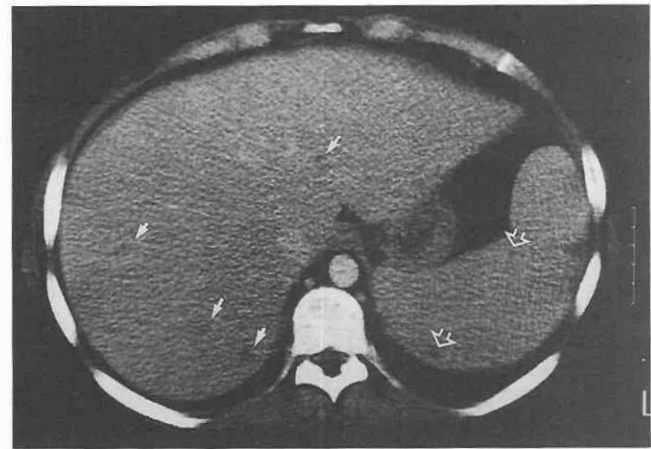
Candidal abscesses. CT image in an immunosuppressed child reveals multiple small low-attenuation microabscesses (arrows) in the liver, with associated microabscesses in the spleen (open arrows).
